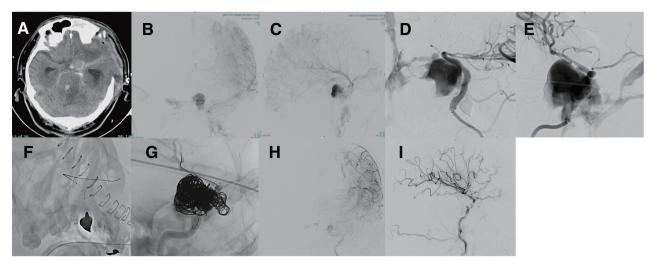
Images of Case 1 during the procedure, 17 days after admission. (A) Plain CT 17 days after admission revealing a diffuse subarachnoid hemorrhage. (B–I) Images taken during the operation, 17 days after admission. (B–E) Left ICA angiography before embolization, showing findings consistent with a CCF and a large aneurysm. (F) Excelsior SL-10 45° (Stryker, Kalamazoo, MI, USA) was placed in the aneurysm, and TransForm C 4 × 10 mm (Stryker) was placed in the left ICA to cover the neck of the aneurysm. (G) Eleven coils were filled in the aneurysm. (H and I) Final angiography during the operation showing complete occlusion of the aneurysm, although a slight drain into the intercavernous sinus remained. CCF, carotid-cavernous fistula; ICA, internal carotid artery
